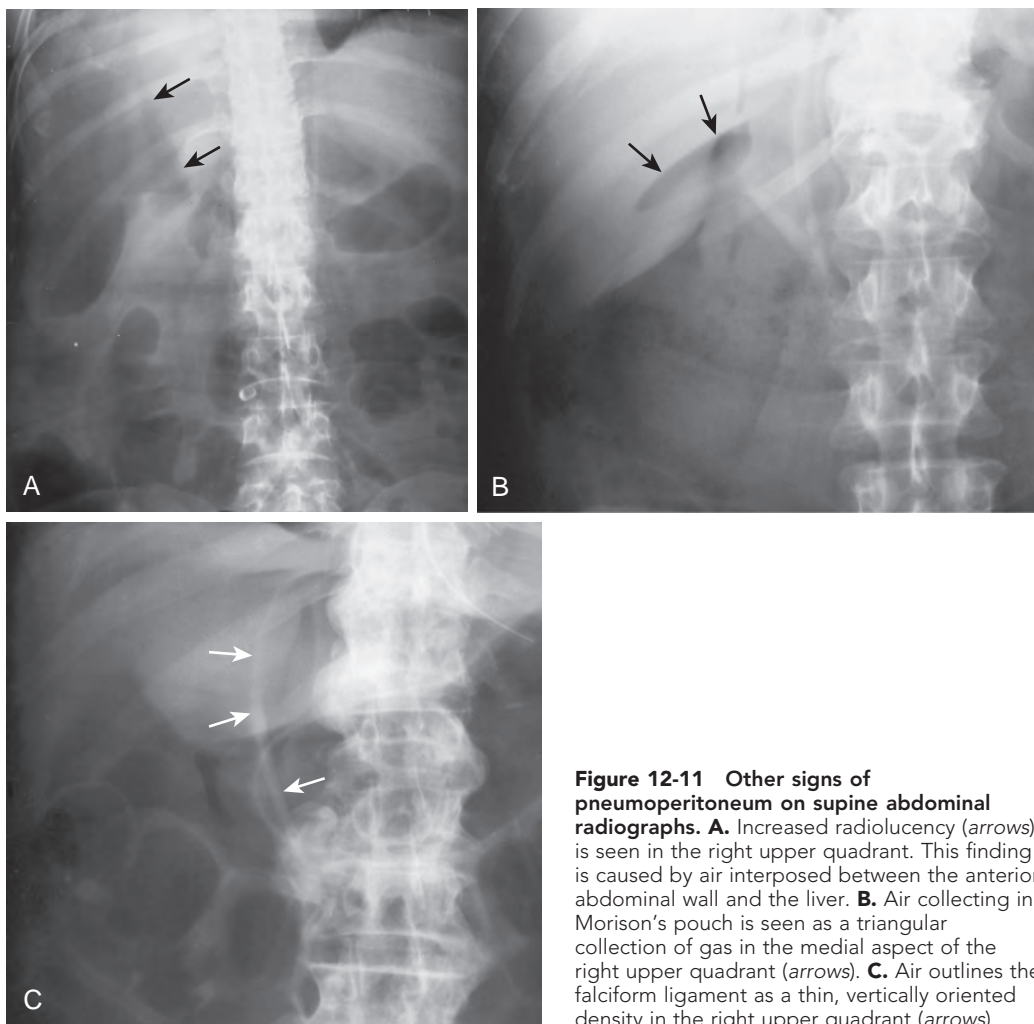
Other signs of pneumoperitoneum on supine abdominal radiographs. A. Increased radiolucency (arrows) is seen in the right upper quadrant. This finding is caused by air interposed between the anterior abdominal wall and the liver. B. Air collecting in Morison's pouch is seen as a triangular collection of gas in the medial aspect of the right upper quadrant (arrows). C. Air outlines the falciform ligament as a thin, vertically oriented density in the right upper quadrant (arrows).
